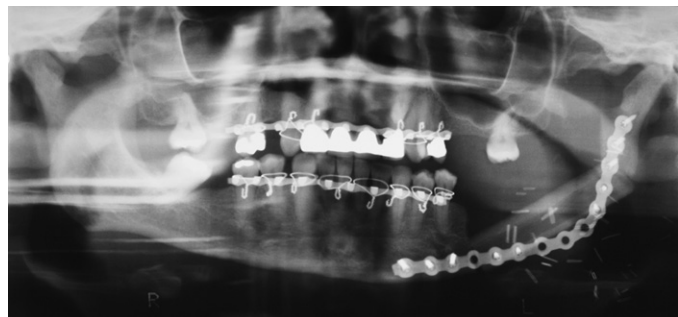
Panoramic radiograph of alveolar and graft vertical discrepancy in fibula free flap primary reconstruction.
